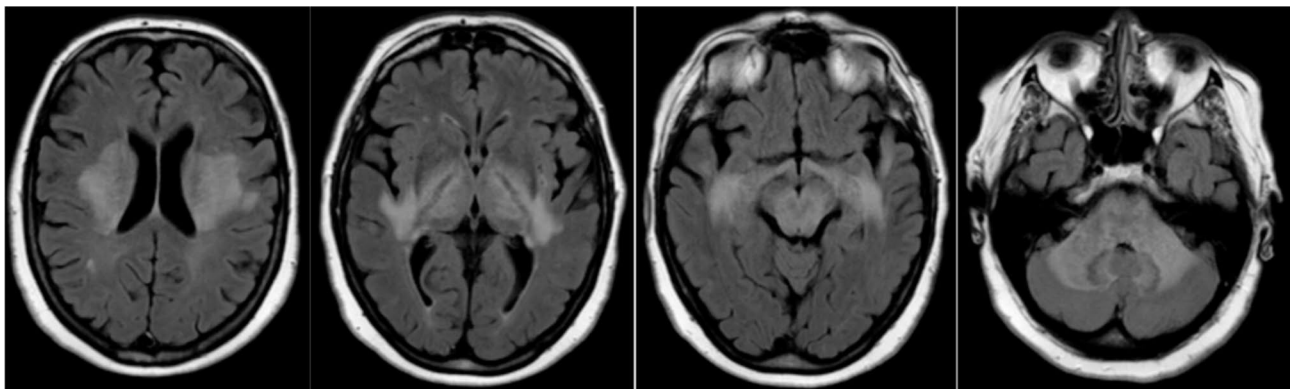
MRI (T2 FLAIR) showing diffuse white matter hyperintensities with diffuse edema
